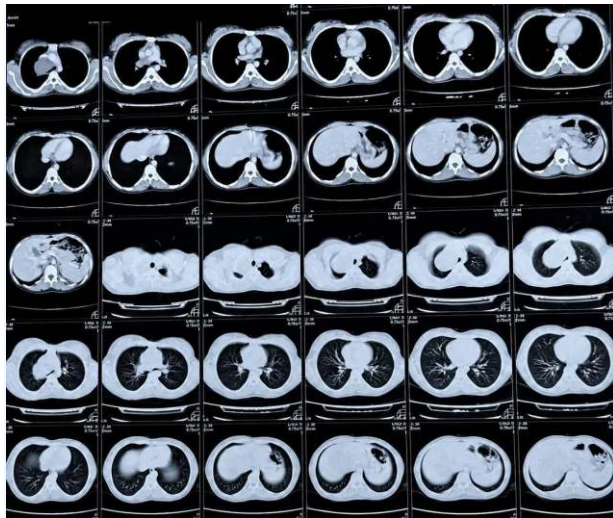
Contrast-enhanced CT chest.
